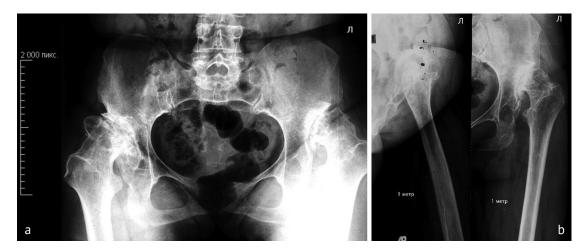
Plain radiograph of the pelvis in a direct projection (*a*) and the left hip joint (*b*) in lateral and direct views before surgery. Bilateral dysplastic coxarthrosis stage III, Crow IV subluxations of the hips: the heads are displaced cranially, are located above the acetabular region, a deficiency of bone tissue is visualized in the area of the anterior, posterior edge and roof of the true acetabulum of the right and left hip joints. Defects of the bone tissue of the acetabulum correspond to type III AAOS
